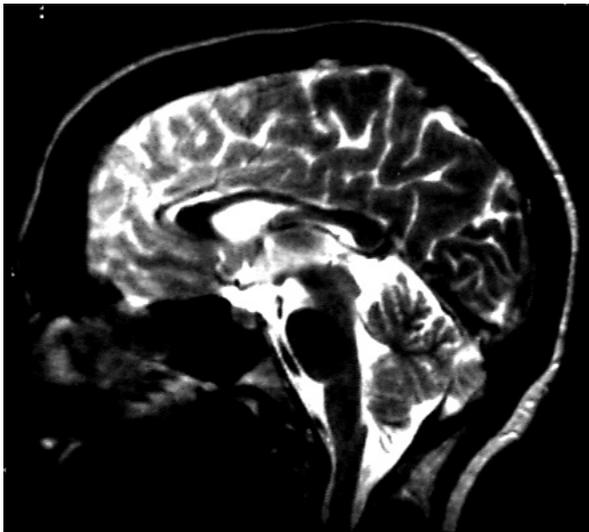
MRI Scan of the brain. Observe the course of the optic chiasma and its relationship to the lamina terminalis
